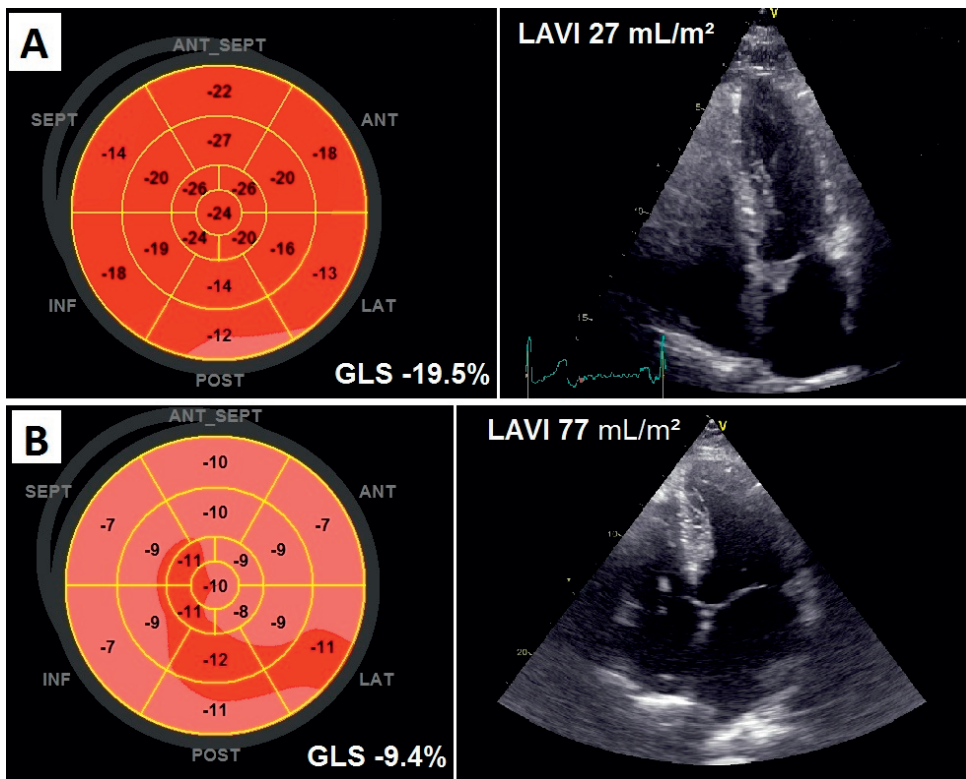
Examples of global longitudinal strain (GLS) displayed in a bull's eye for the 17 left ventricular segments (color coded from dark red, as preserved GLS, to pink as impaired GLS) and left atrial volume index (LAVI) assessment. Panel A. A 55-year old patient with normal GLS and LAVI who did not experience an event during 7.5 years of follow-up. Panel B. A 42-year old patient with both abnormal GLS and LAVI that experienced appropriate ICD therapy 2.5 years after baseline echocardiography.
